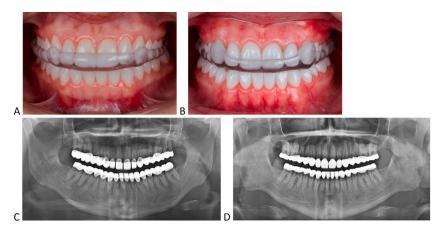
Maintenance and follow-up. A, Delivery of nocturnal occlusal device, sibling A. B, Delivery of nocturnal occlusal device, sibling B. C, Panoramic radiograph, sibling A. D, Panoramic radiograph, sibling B.
